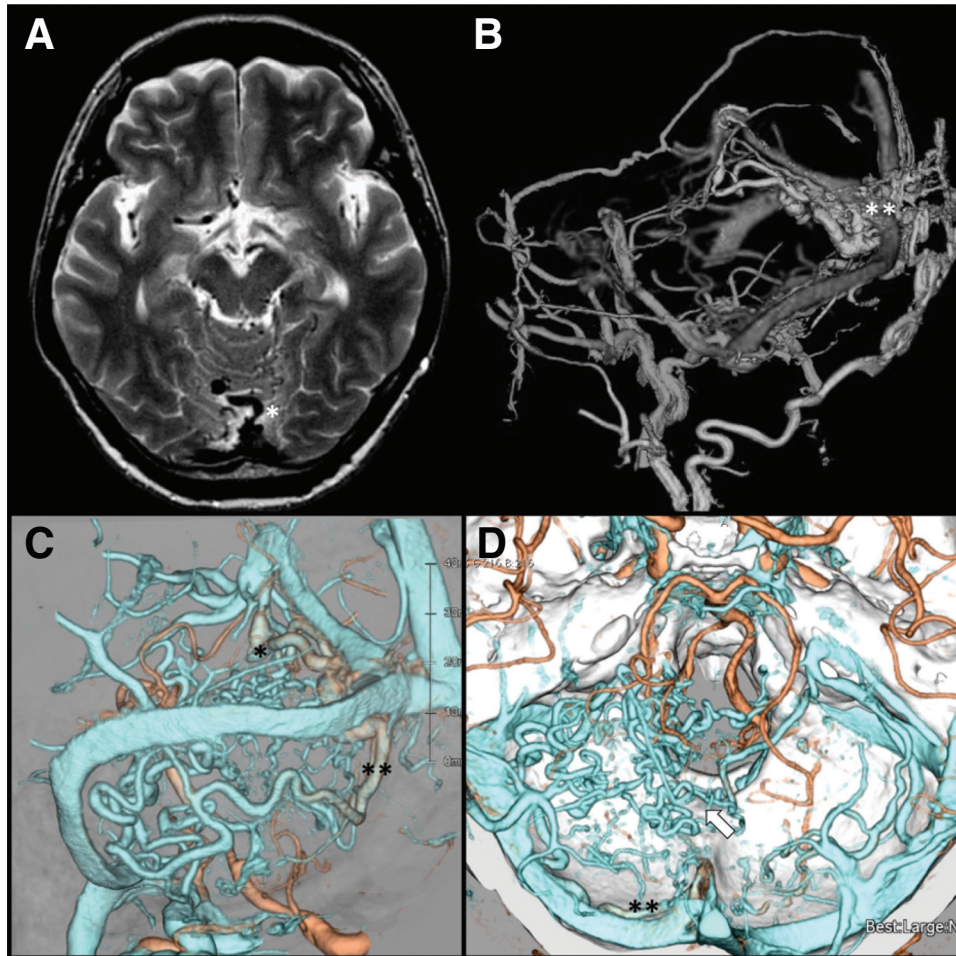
T2-weighted image (A) showed markedly enlarged cerebellar veins and two SVVs (white asterisk). Fused 3D-DSA (B) showed a tentorial arteriovenous fistula, fed mainly by the bilateral MMA and bilateral OAs with the fistula point at the torcular (double white asterisks), draining into two SVVs. Fused 3D CTA and venography (C and D) showed the venous drainage into the two SVVs, the inferior vermian vein (double black asterisks), and markedly dilated cerebellar veins (white arrow). MMA: middle meningeal arteries; OAs: occipital arteries; SVVs: superior vermian veins
